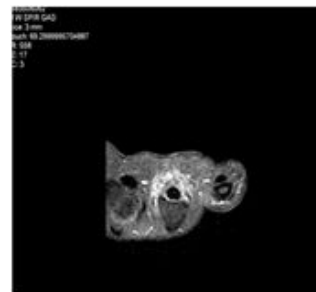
MRI image (crosssectional view) showing the mass encircling the flexor tendons of the finger.
